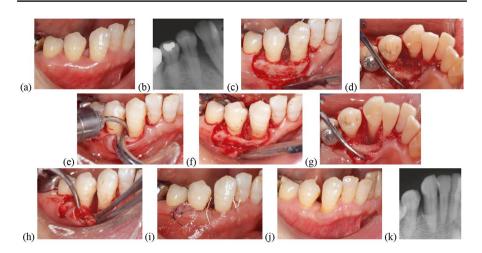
a, b After initial therapy, a 9 mm pocket with bleeding on probing remains on the distal of the mandibular right cuspid. c, d Elevation of a flap with the granulation tissue filling the pocket when viewed from the buccal and lingual aspects. e An Er:YAG laser is used with an 80° curved, 600 μ -diameter tip at 1.2 W average power (40 mJ per pulse at 30 Hz) with a saline water spray for debridement. f, g Clean vertical bone defect with no thermal damage from the laser energy. h The laser is used with the same parameters to decontaminate and stimulate gingival flap tissue. i Suturing the flap in place. j 8-Year postoperative view showing healthy gingival tissue with some recession. A 7 mm pocket depth reduction with 5 mm of clinical attachment gain. k 8-Year postoperative radiograph (Case photos and details modified from Aoki et al. (reference #2) with permission © copyright 2015 John Wiley and Sons A/S)
